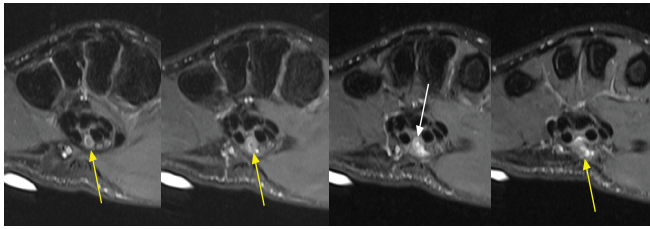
Sequential axial T2-weighted fat-suppressed MR images from proximal to distal demonstrate the thrombosed persistent median artery (arrows), with mild fusiform enlargement, surrounding T2-hyperintense perivascular edema, and intrinsic signal abnormality (dashed arrow).
